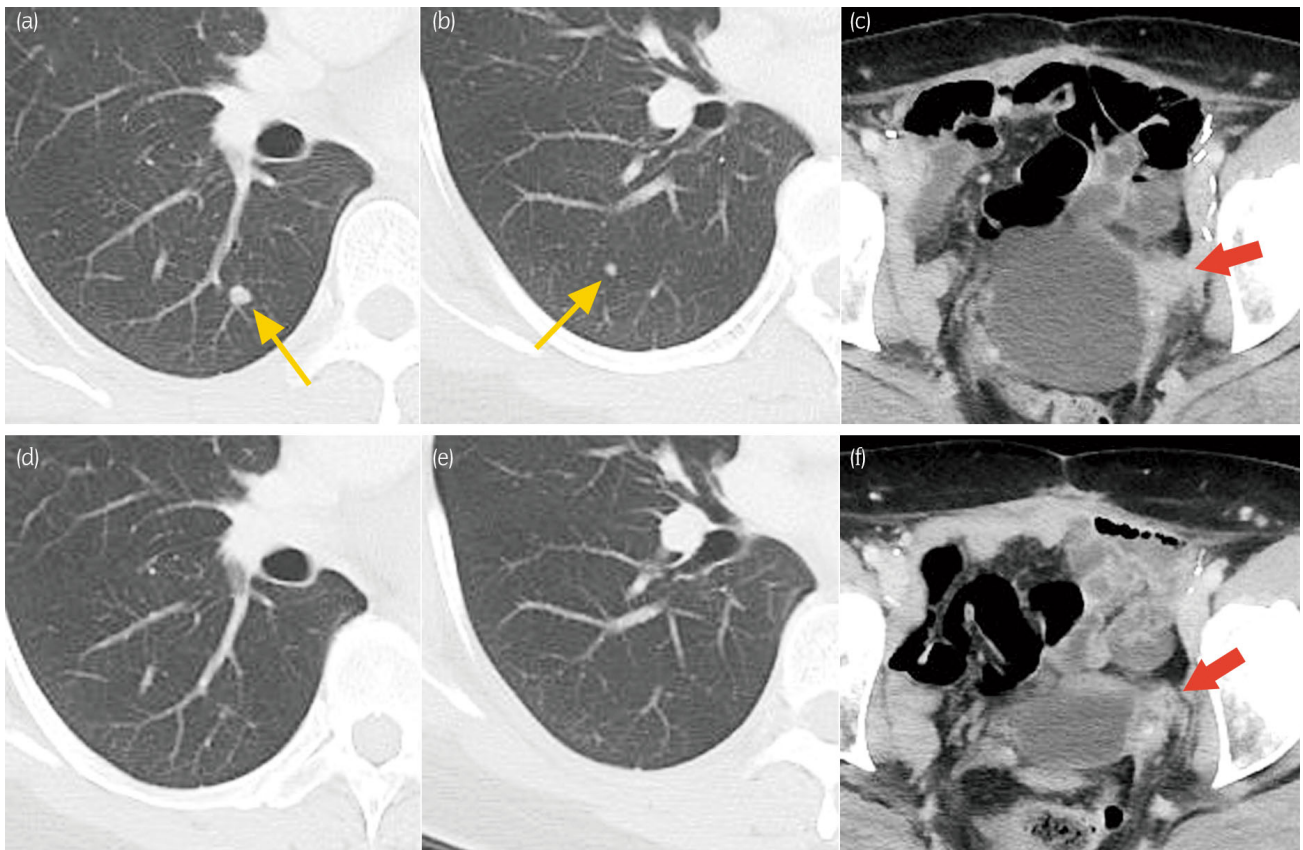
Upper row: CT scans at recurrence. (a), (b) Two metastases in the lower lobe of the right lung (yellow arrows). (c) Local recurrence on the left side of the bladder (red arrow). Lower row: CT scans 14 months after discontinuing the chemotherapy. (d), (e) The lung metastases had disappeared. (f) The local recurrent lesion remained regressed (red arrow).
